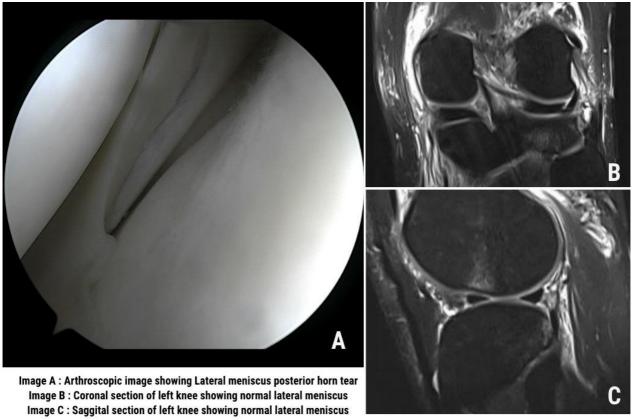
Lateral meniscus tear seen during arthroscopy procedure but reported negative on MRI
